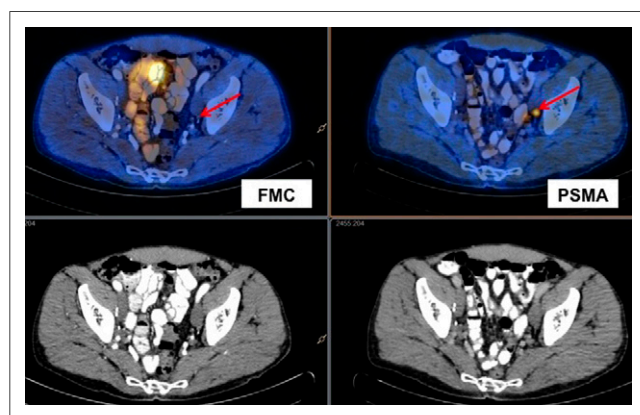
A 62-y-old man with Gleason 7 prostate cancer treated with radical prostatectomy and salvage radiation who presented with rising PSA level (0.4) and PSA doubling time of 8 mo. ^{18}F -fluoromethylcholine (FMC) PET/CT findings were negative, whereas ^{68}Ga -PSMA PET/CT scan demonstrated single positive left obturator lymph node (maximum standardized uptake value, 3.7). Subsequent biopsy confirmed prostate cancer recurrence.
